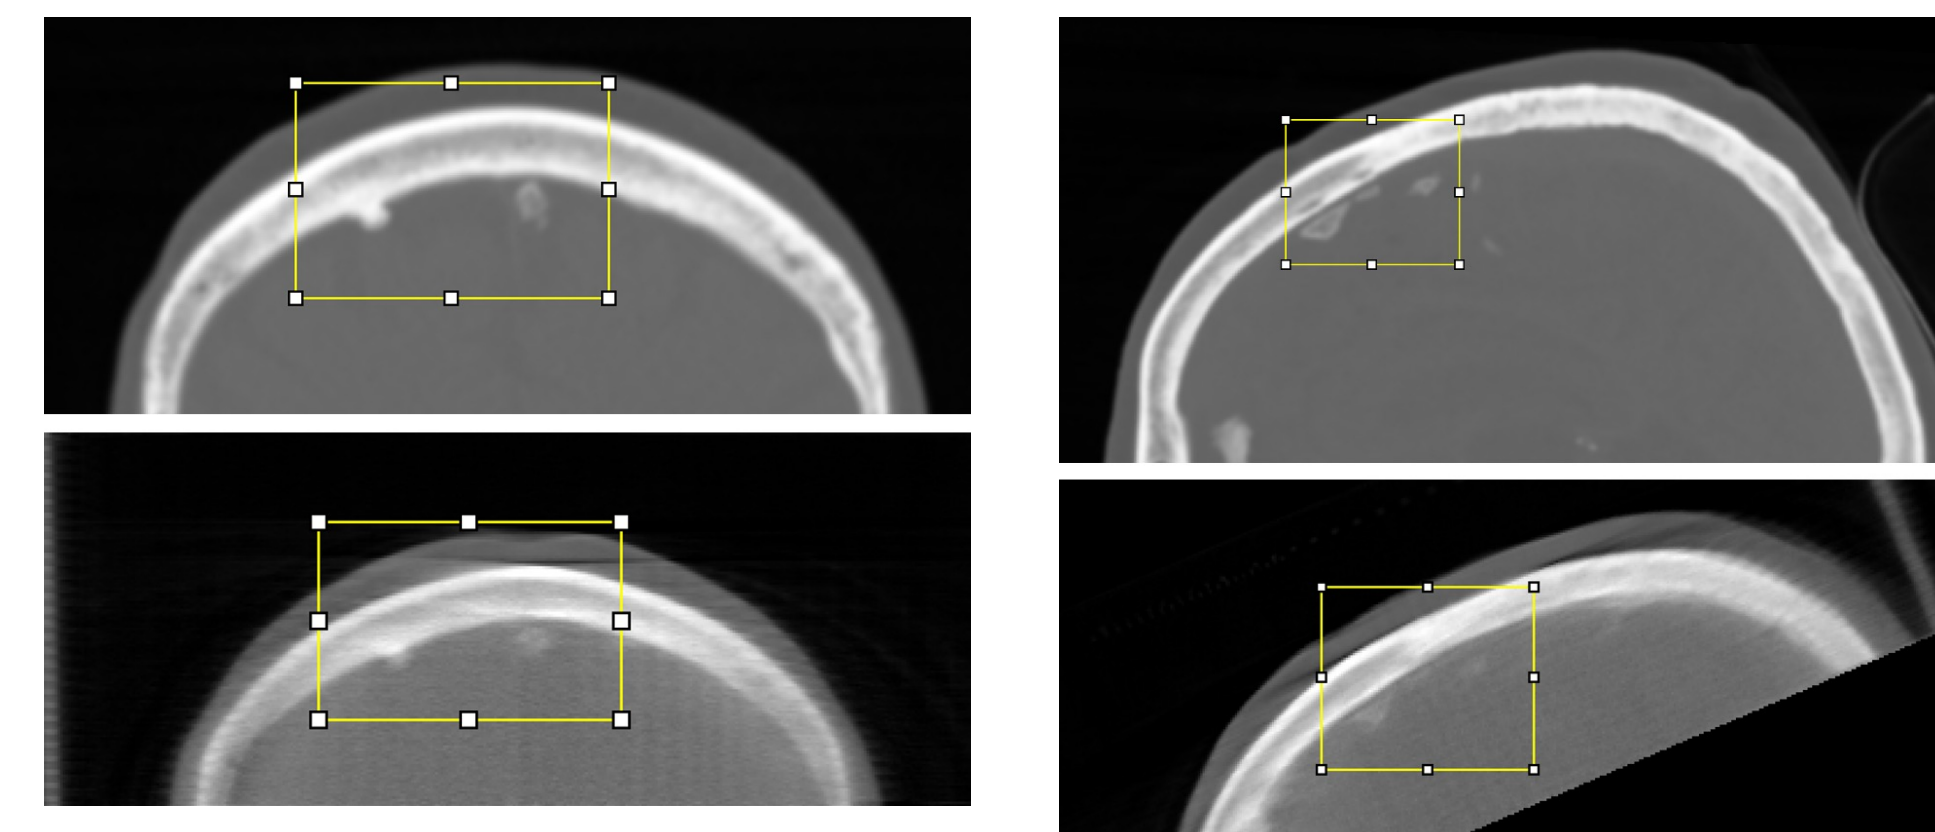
Calcifications in parietal lobe presented in coronal slice of both the SIEMENS clinical head CT (top) and the CNT s-HCT prototype (bottom) of Subject 5
